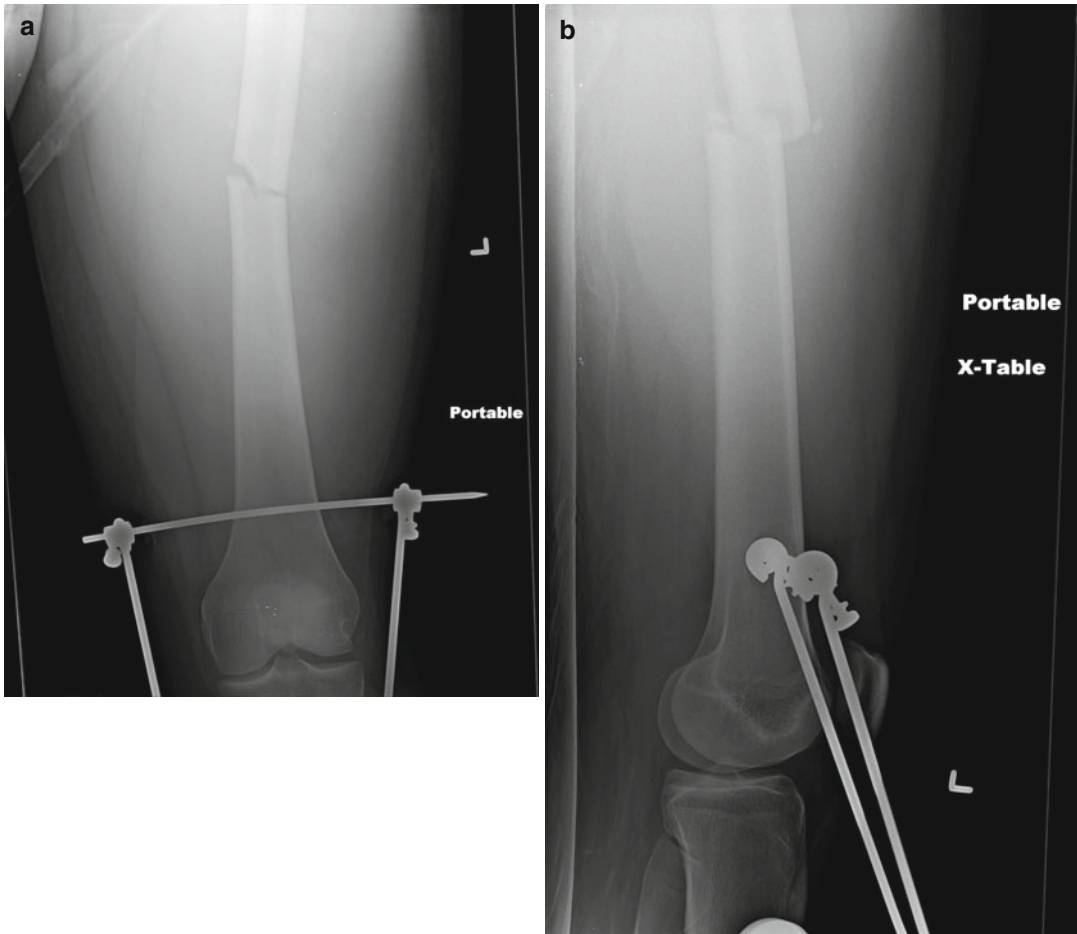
An AP (a) and lateral (b) radiograph of the knee following placement of a distal femoral traction pin. Note the position of the pin approximately 3 cm proximal to the superior pole of the patella and slightly anterior. This pin
